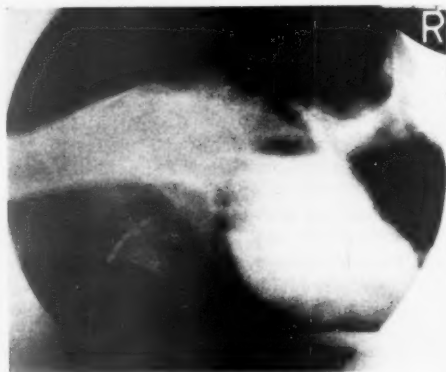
Radiograph of the bladder containing sodium iodide with the patient prone. There is air in the balloon, and Myodil in the lumen of the catheter.
